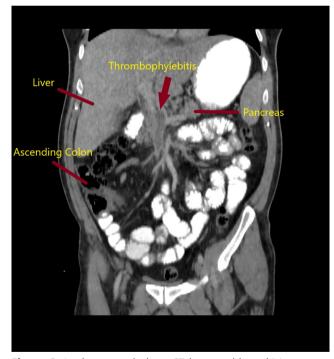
In the coronal plane CT image with oral-IV contrast, a hypoattenuating thrombus extending from the SMV to the portal vein is observed (red arrow)
